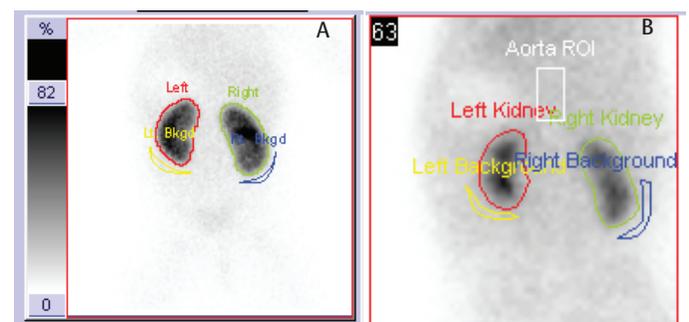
Regions of interest drawn in ^{99m}Tc-DMSA (A) and dynamic renal scintigraphy (B)
